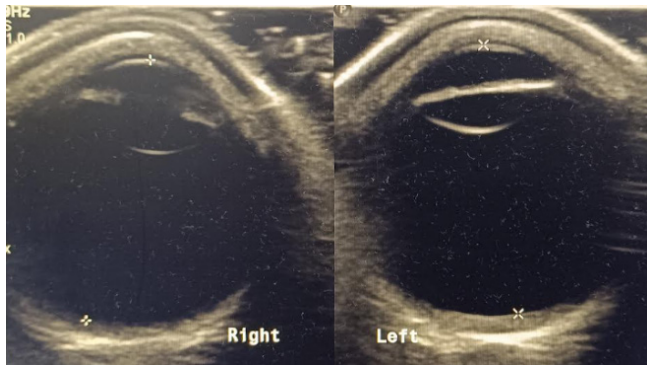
Ultrasonography did not reveal the presence of foreign body
